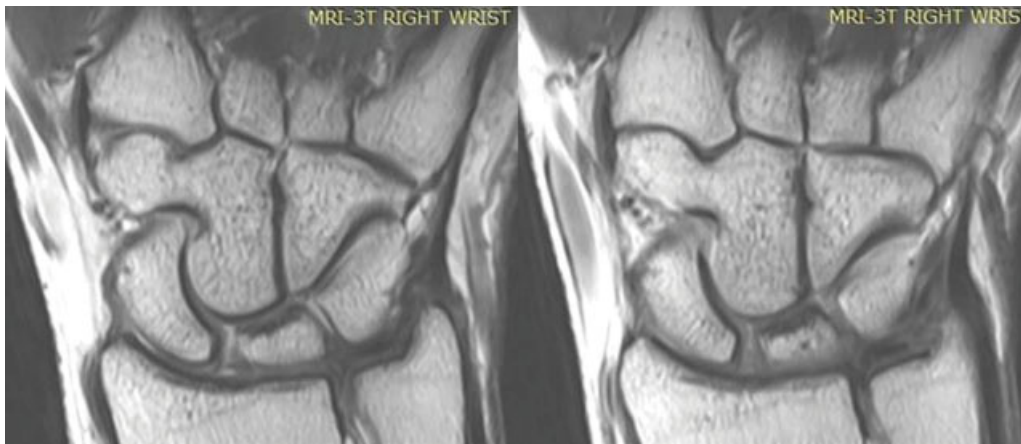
Coronal slices of proton-density-weighted MRI scan of the right wrist with contrast, demonstrating complete osseous ICTC. ICTC, isolated capitate-trapezoid coalition; MRI, magnetic resonance imaging.
